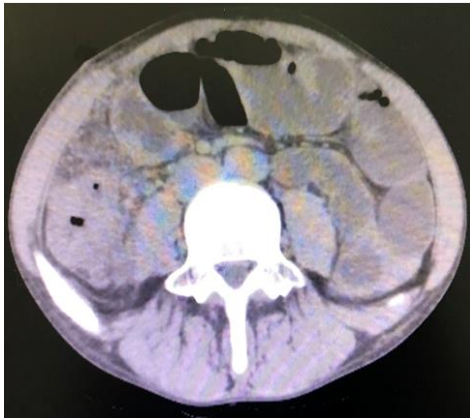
Abdomen Computed Tomography without contrast showing cecum and terminal ileum thickened with surrounding fluid, in addition to nodes enlargements.
